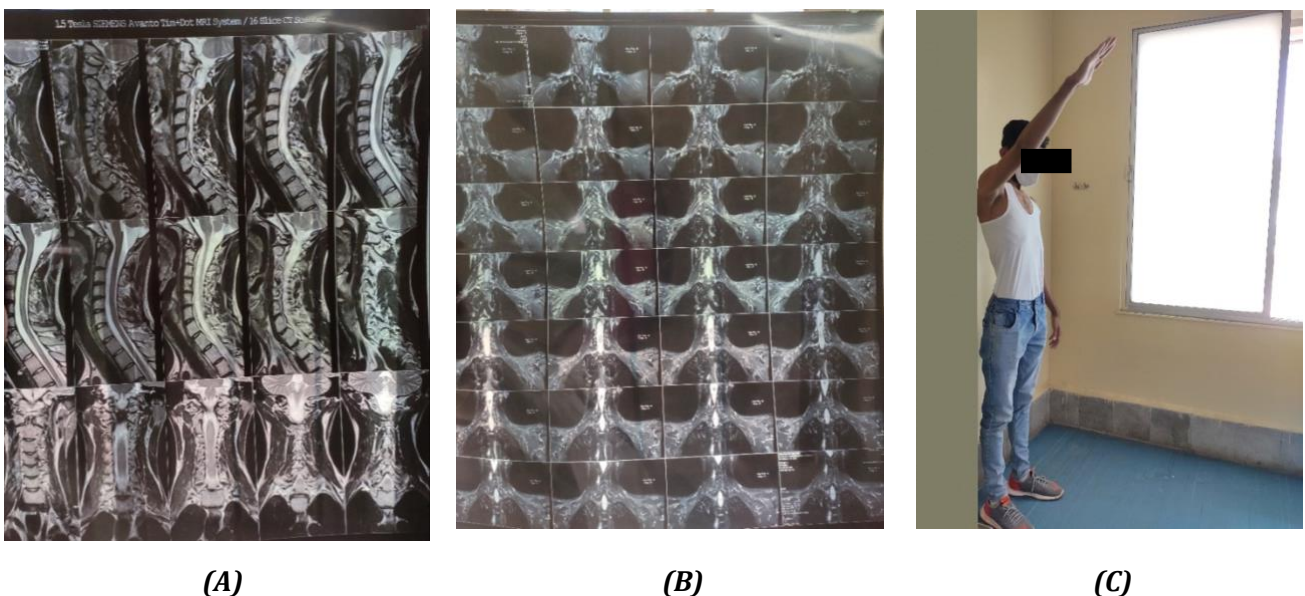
(A) shows MRI projection of lateral section of cervical spine, (B) shows MRI projecting atrophy of right supraspinatus muscle, (C) Patient performing shoulder flexion
